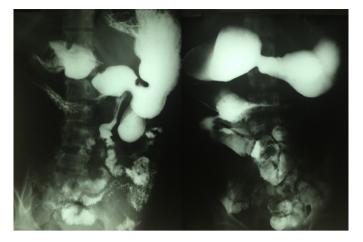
Contrast radiographic study showing a duodenal stenosis in the third portion of the duodenum and the megaduodenum.
